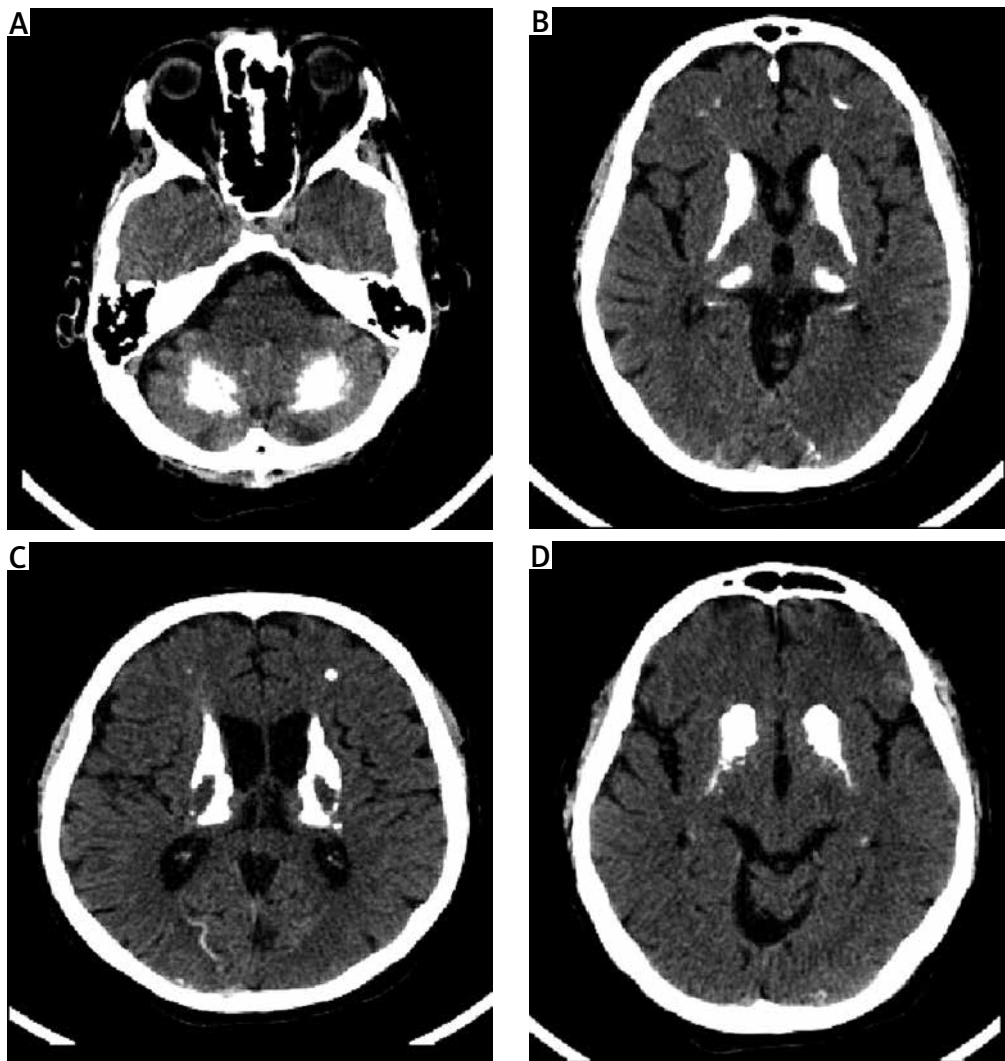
Computed tomography (CT) findings in patient 1: brain CT shows brain calcification in dentate nuclei of the cerebellum (A), basal ganglia, thalamus and cortical (B-D).
